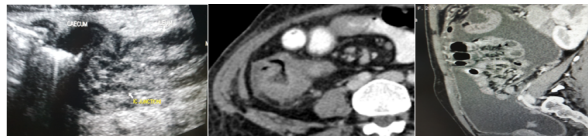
USG and CT images showing wall thickening of ascending colon with mildly increased vascularity on doppler.
